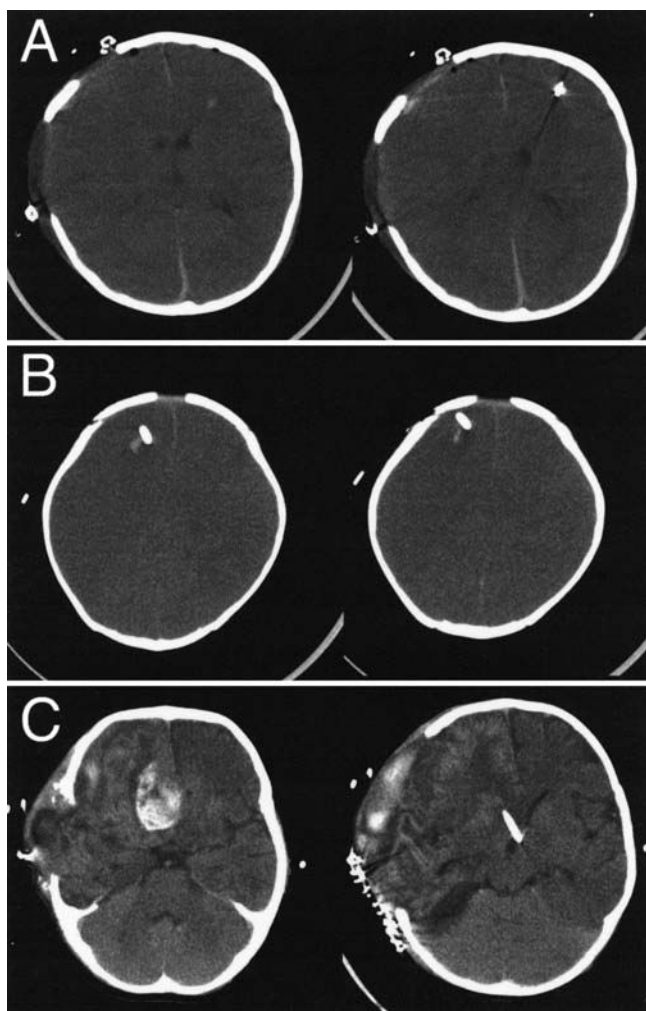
Axial unenhanced head CT scans demonstrating Grades I (A), II (B), and III (C) hemorrhages.
